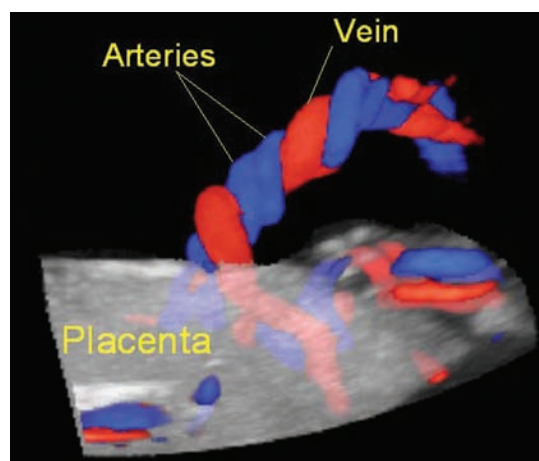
3D color Doppler ultrasound showing a posterior placenta with central insertion of the umbilical cord.
